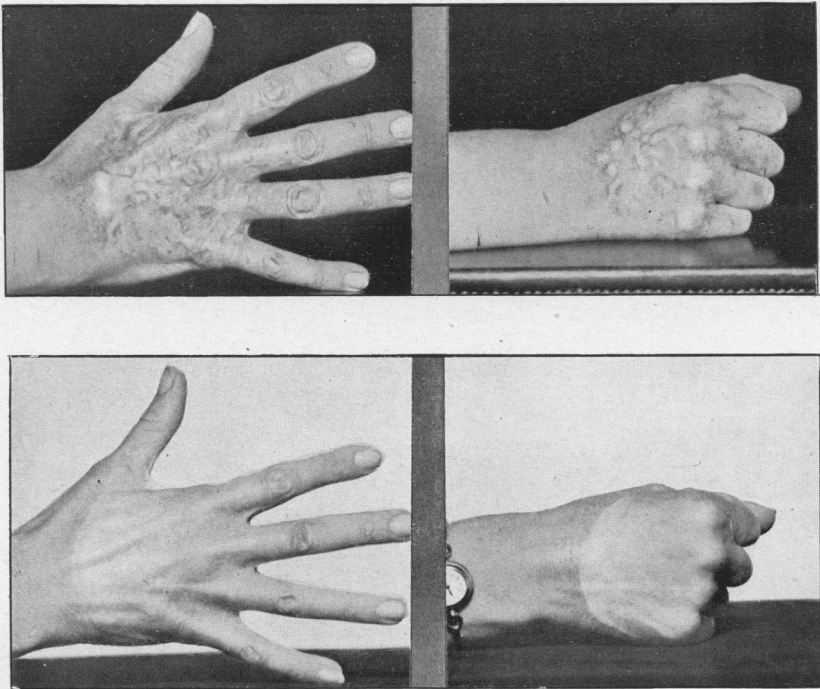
X-ray burns of hand. Excision of scar tissue and Thiersch graft.
